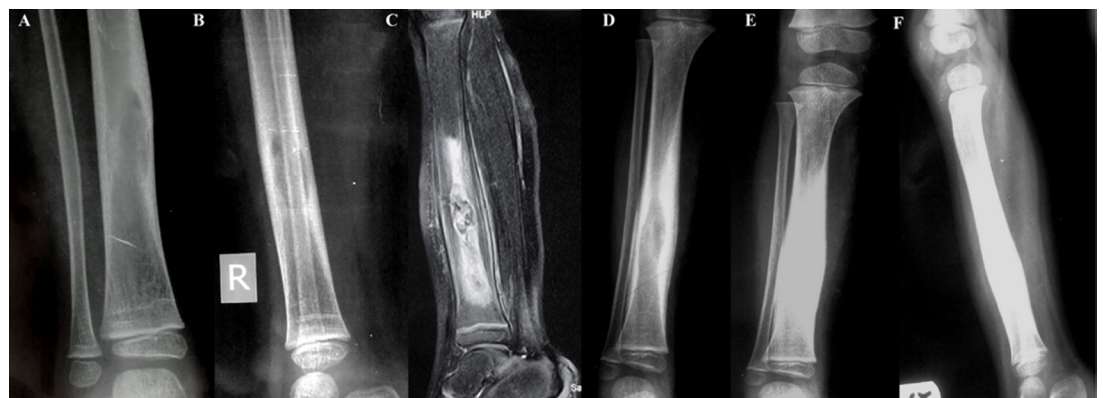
(A) Anteroposterior and (B) lateral view radiographs of the right tibia showing a large radiolucent area in the diaphysis (arrow) suggestive of a lytic intramedullary bone lesion extending into the endosteal surface of medial cortex (C) MRI T2-weighted sagittal section of right tibia showing a circumscribed, heterogeneous, necrotic area in the medullary canal with surrounding oedema and cortical sequestrum. The overlying cortex is thickened due to endosteal new bone formation with cortical breach (arrow) and mild swelling of the overlying soft tissue. (D) Anteroposterior radiograph of the right tibia after 1 year of treatment showing cortical thickening and sclerosis indicative of ongoing healing (E) Anteroposterior and (F) lateral view radiographs at 2 years follow-up showing marked sclerosis and healing of lesion.
